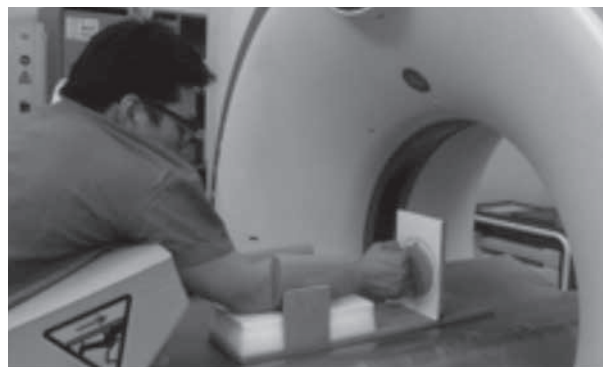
Computed tomography was performed with the subject lying pronated, the shoulder in neutral rotation and 90° forward flexion, and the elbow in 45° of flexion.
